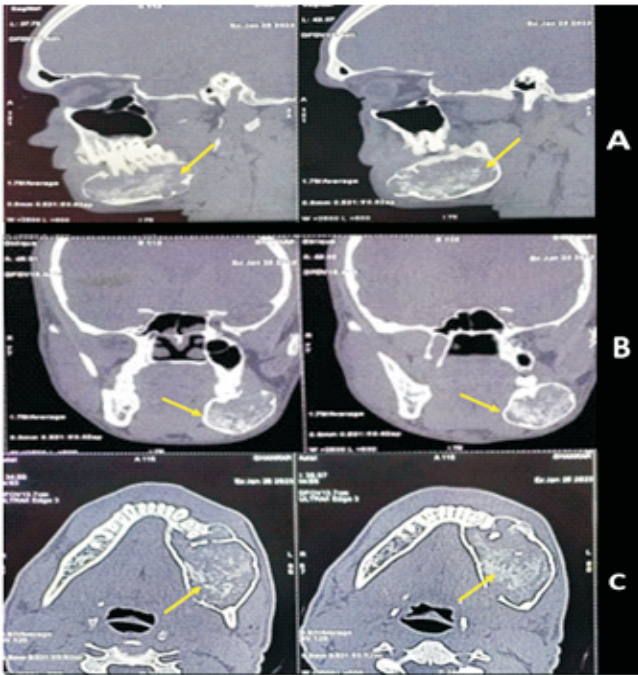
Computed tomography scan of Sagittal section (A), coronal section (B), and Axial Sections showing the expansile lytic lesion with non-coalescing hyperdense calcific foci within the lesion.
